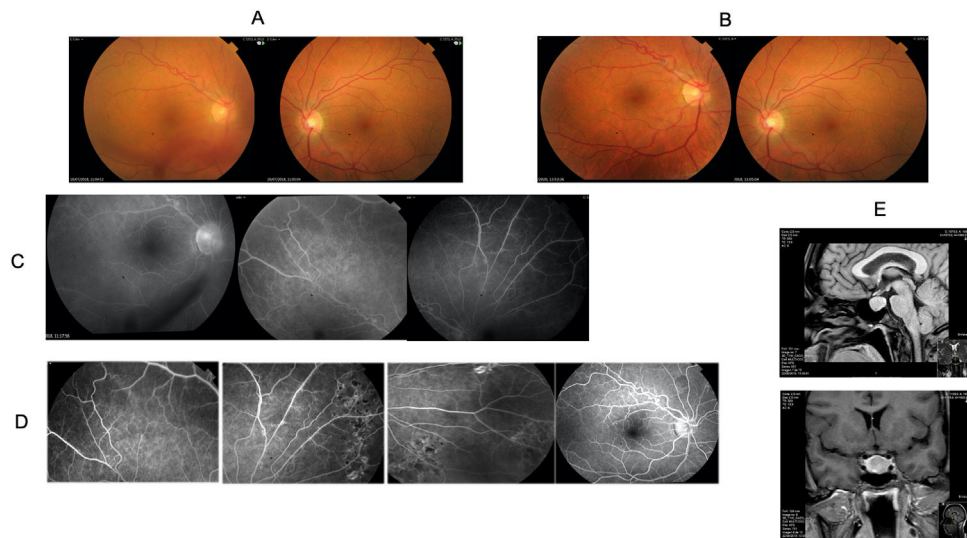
Retinographies, fluorescein angiography and pituitary magnetic resonance imaging. A) Initial retinography showing vitreous haemorrhage. B) Follow-up retinography. C) Initial fluorescein angiography: superior temporal retinal arcade of the RE with vascular abnormality (venous stenosis and prominent vascular loops) on the periphery. No neovessels and no areas of vascular ischaemia. D) Follow-up fluorescein angiography showing laser scars and no neovessels. E) Pituitary magnetic resonance imaging: a pituitary adenoma measuring 14 mm x 20 mm x 14 mm that displaced the pituitary stalk to the right, compressed the pituitary gland, caused bulging of the diaphragma sellae and extended to the left cavernous sinus (Knosp grade 2). No compromise of the optic chiasm.
